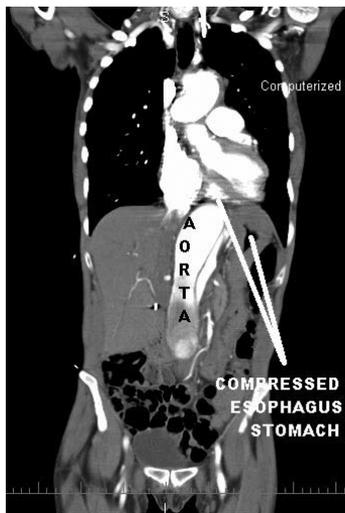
Computed tomography angiography scan of the abdominal cavity in coronal section demonstrating the extent and location of the dissecting aneurysm of abdominal aorta and associated compression/stretching of the lower esophagus and stomach.
